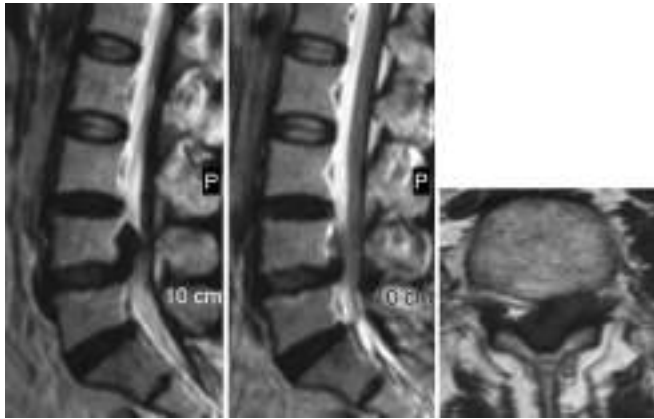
MRI showing L4-L5 disc herniation which had caused footdrop
